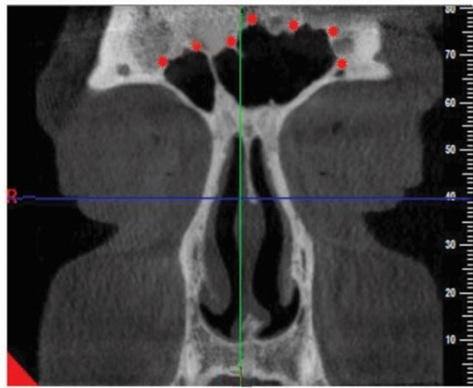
A coronal CBCT cross-section, showing the scalloped border of the frontal sinus
